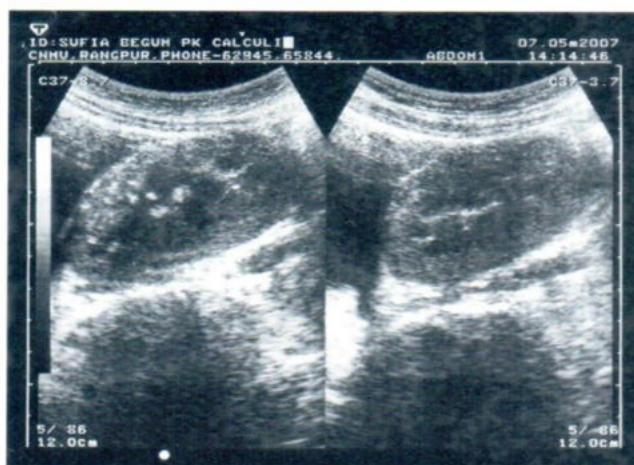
Tiny calculi in pelvic kidney seen in ultrasound scan
